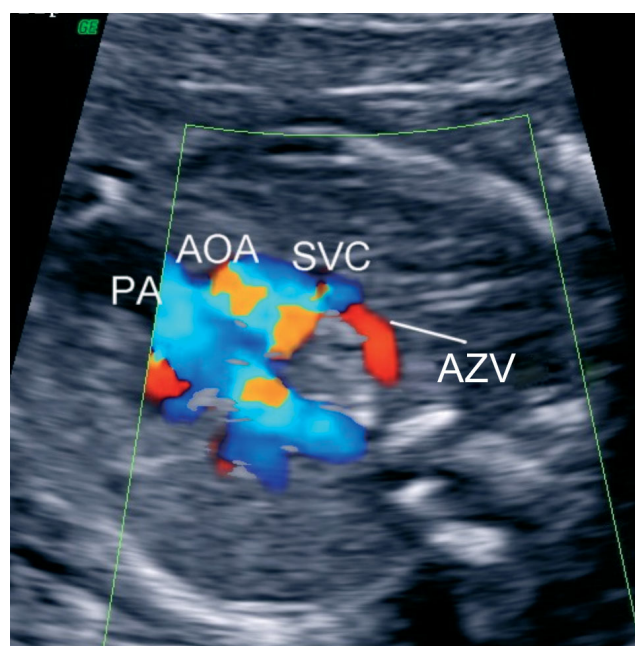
Color Doppler mapping showing azygos vein (AZV) connection to the superior vena cava (SVC). Note the right, retrotracheal and posteroanterior course of the azygos vein, compared with the retrotracheal, left-to-right course of the aberrant right subclavian artery in Figure 5. AOA, aortic arch; PA, pulmonary artery.
